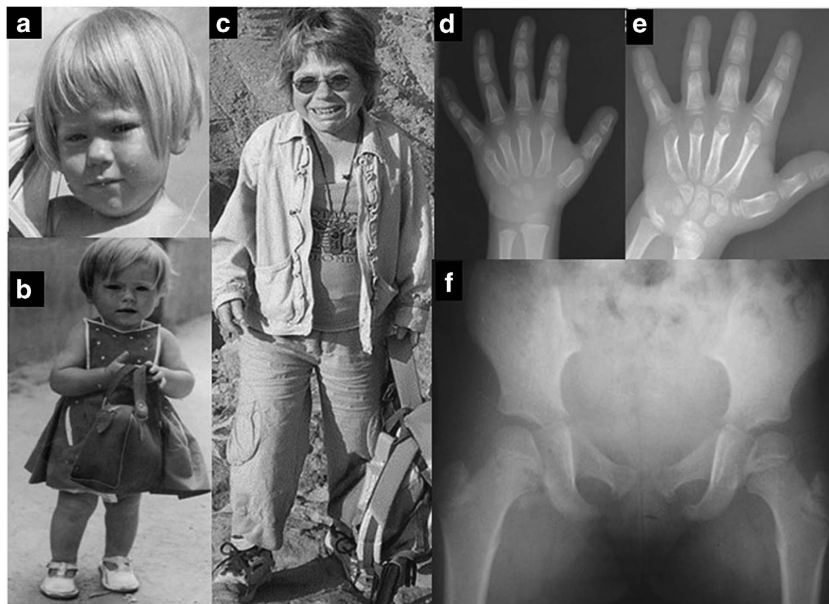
Clinical and radiological manifestations of acromelic dysplasia. AD patient at 6 (a), 3 (b) and 62 years old (c), respectively. (d, e) Hand and (f) pelvic X-rays of an AD patient at 10 years of age. Note the delayed bone age, internal notch of metaphysis of the fifth, fourth and third metacarpals and cone-shaped epiphysis of the phalanges. Note the internal notch of the femoral epiphysis, coxa valga and acetabular dysplasia.
